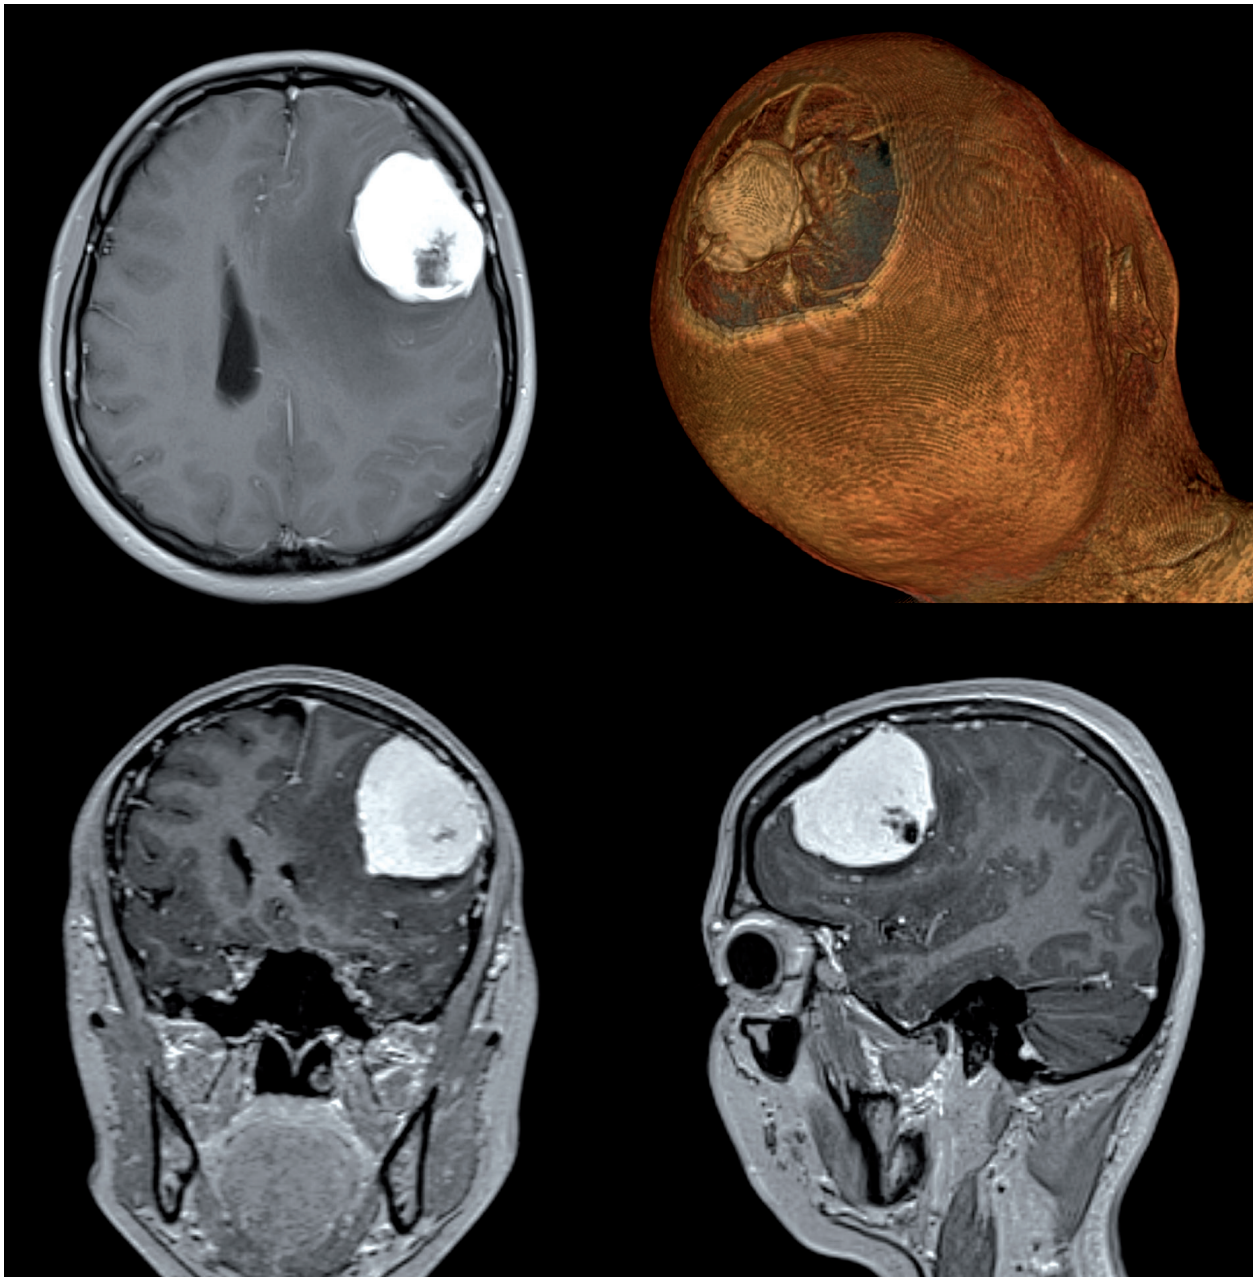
MRI of left frontoparietal meningioma with peritumoral oedema. Photo credit: Department of Neurosurgery, Copernicus Hospital in Gdansk
